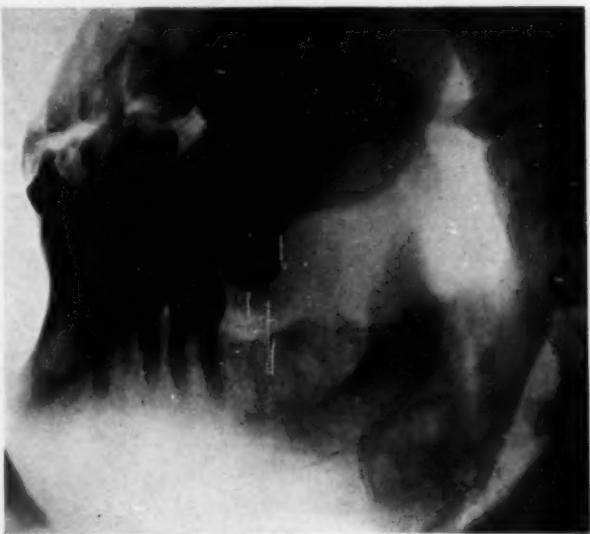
Case II. Radiograph showing enlargement of left condyle.
